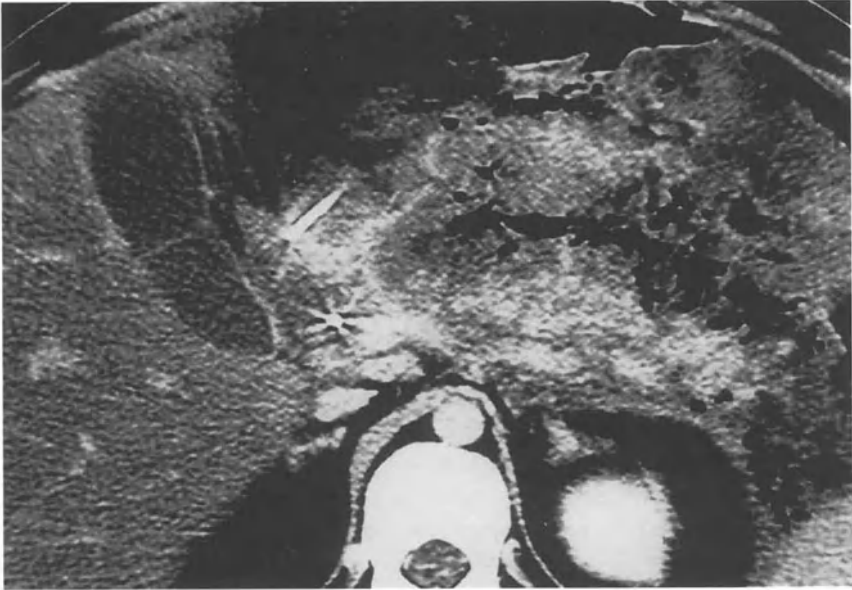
Diffuse whole gland necrotic degeneration with positive bacterial culture. Gas bubbles are typical indicators of infected necrosis as well as late and unfrequent x-ray findings (Personal experience)
